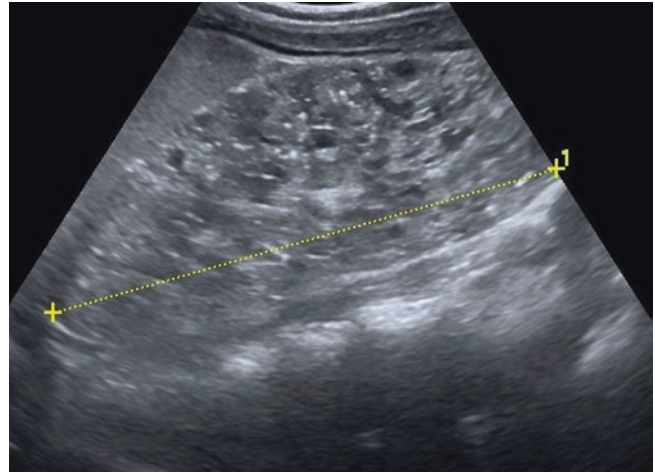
Ultrasound coronal section of right kidney reveals enlargement with loss of normal architecture due to the presence of multiple tiny cysts in a child with autosomal recessive polycystic kidney disease
